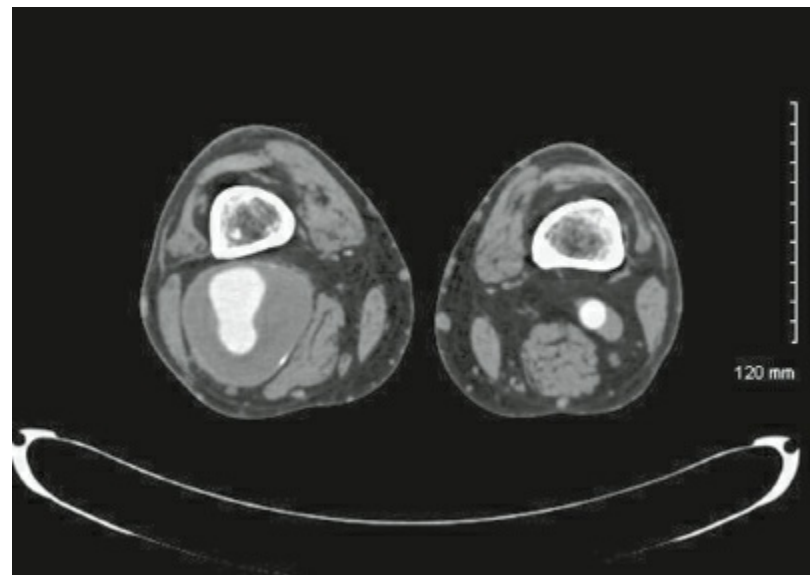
Computed tomography of large right popliteal aneurysm with significant laminar thrombus present.
